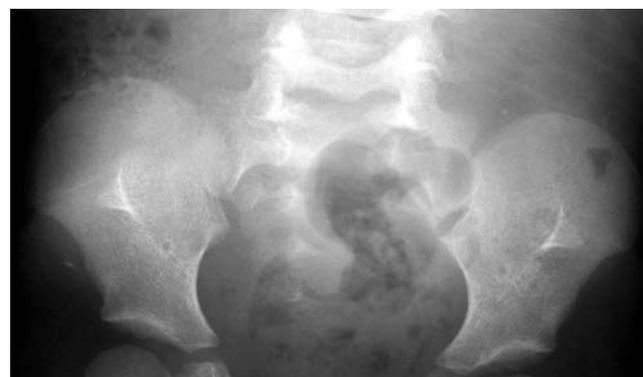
Radiograph of the pelvis of an approximately 4-year-old girl who has nail–patella syndrome. She has short stature, dystrophic nails, and absent patellae. The radiograph shows bilateral iliac horns, which were asymptomatic.
